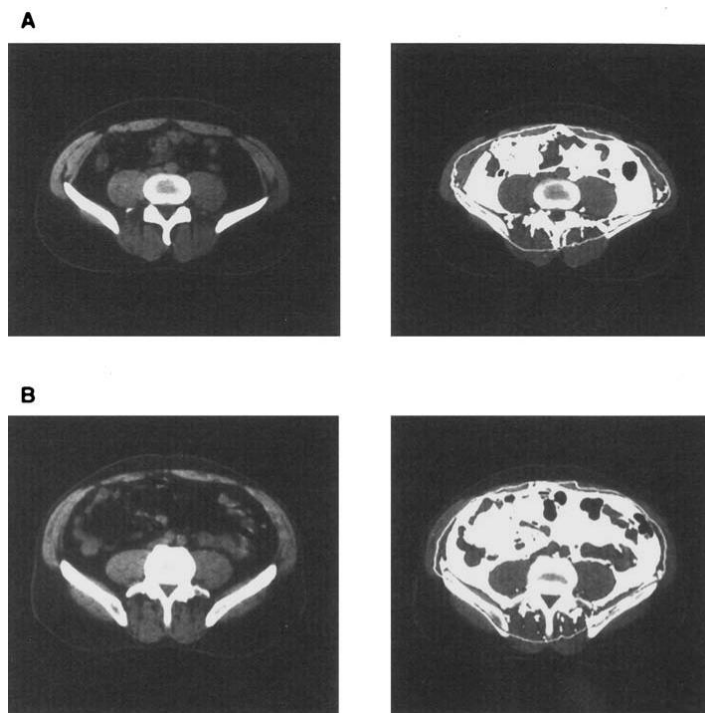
Cross-sectional images of the abdomen obtained by computed tomography for a young man (A) and a middle-aged male (B), both with the same total body fat mass. [Modified from Despres et al. (68).]
